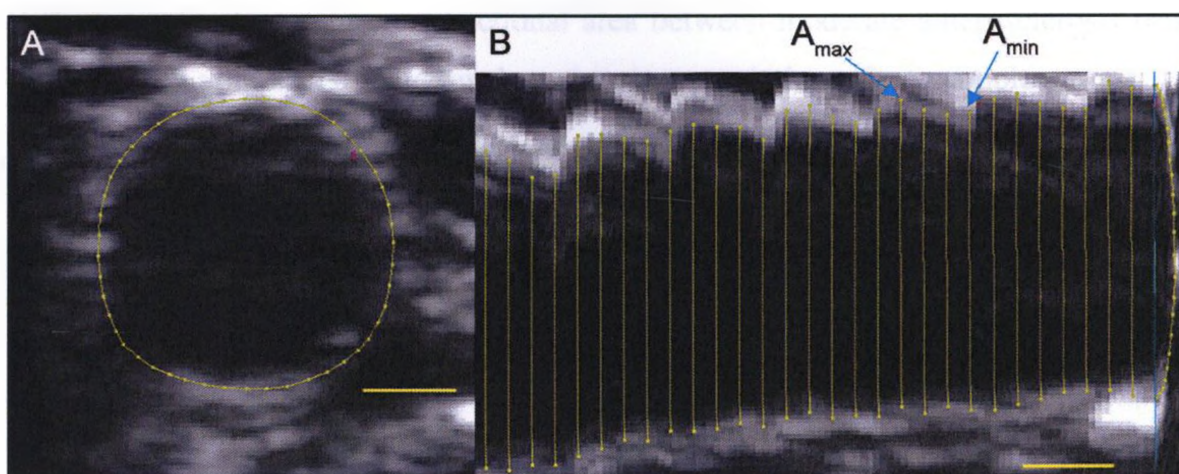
Ultrasound Image Analysis.
